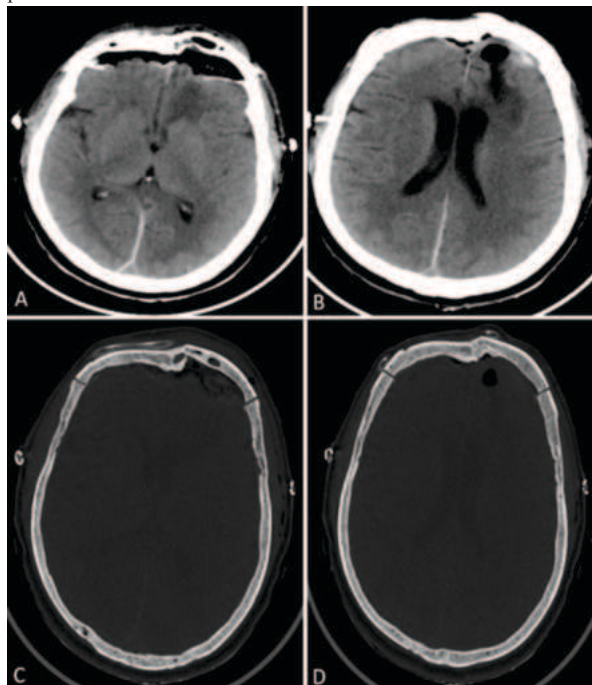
CT Brain Parenchyma (A,B) Axial view showing hypodense area with air pockets involving the left frontal region with significant reduction in midline shift.
